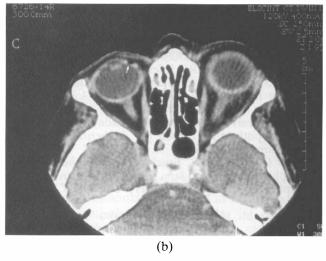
(a) Axial spiral CT scan (2.5 mm slice) showing proptosis of the left eye with retrobulbar streaky shadows, thickened sclera and optic nerve. There is peribulbar inflammation. A gas bubble is noted (arrow) overlying the anterior chamber. The left maxillary sinus shows mucosal thickening, but there is no subperiosteal inflammation. (b) Axial spiral CT scan (2.5 mm slice) showing proptosis of the left eye with retrobulbar streaky shadows, thickened sclera and optic nerve. A gas bubble (arrow) is noted anterior to the right globe in the conjunctival fornix.
